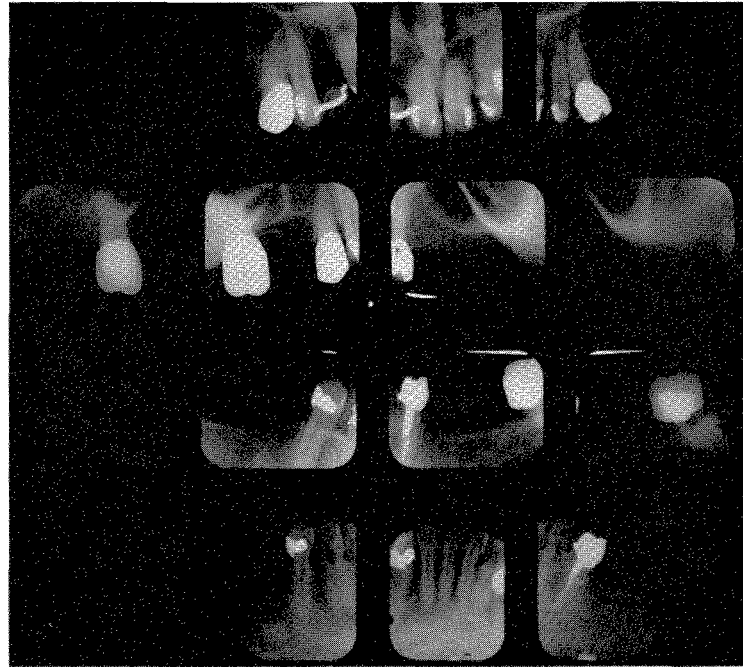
Roentgenograms taken in September, 1940, four years after completion.
